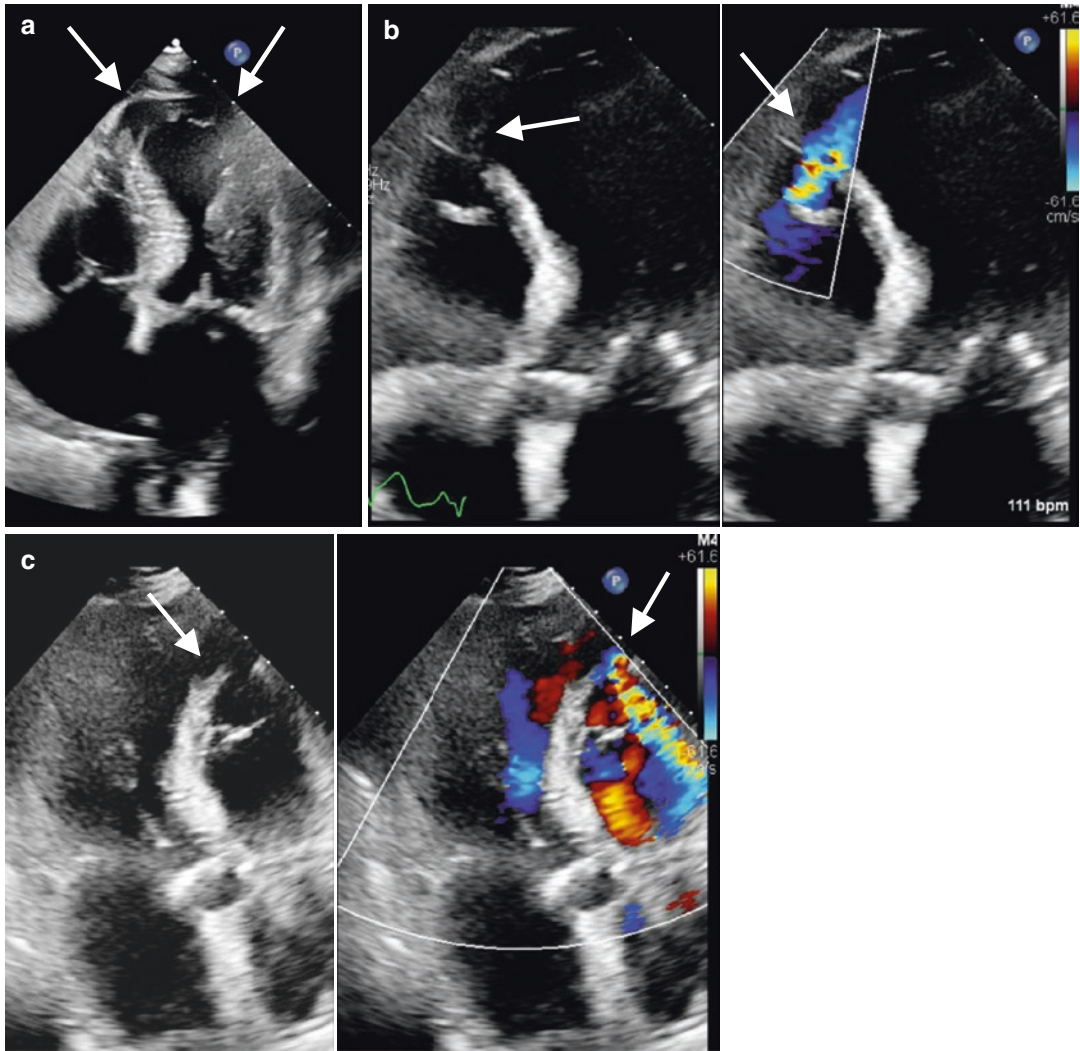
The TTE images show sequela of a large myocardial infarction with panel (a) showing apical four chamber image with akinesis of the mid to apical walls and panels (b, c) color Doppler of a large interventricular muscular ventricular septal defect (VSD) with left to right
